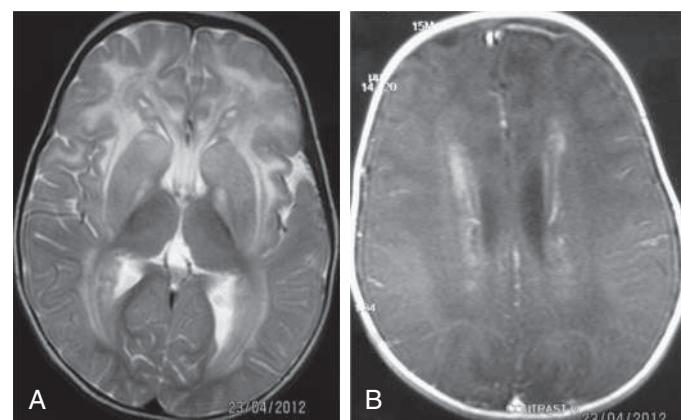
Alexander disease. MRI of the index patient at the age of 15 mo. A, Axial T2-weighted sequences (TR/TE: 4000/99) at the basal ganglia and thalamus level demonstrating diffuse bilateral, symmetric increased signal predominantly of the frontal periventricular but also of the subcortical, white matter and the basal ganglia. B, Significant periventricular rim after intravenous gadolinium infusion (T1-weighted sequences; TR/TE: 400/88). (From Zafeiriou DI, Dragoumi P, Vargiami E. Alexander disease. *J Pediatr.* 2013;162:648.)
